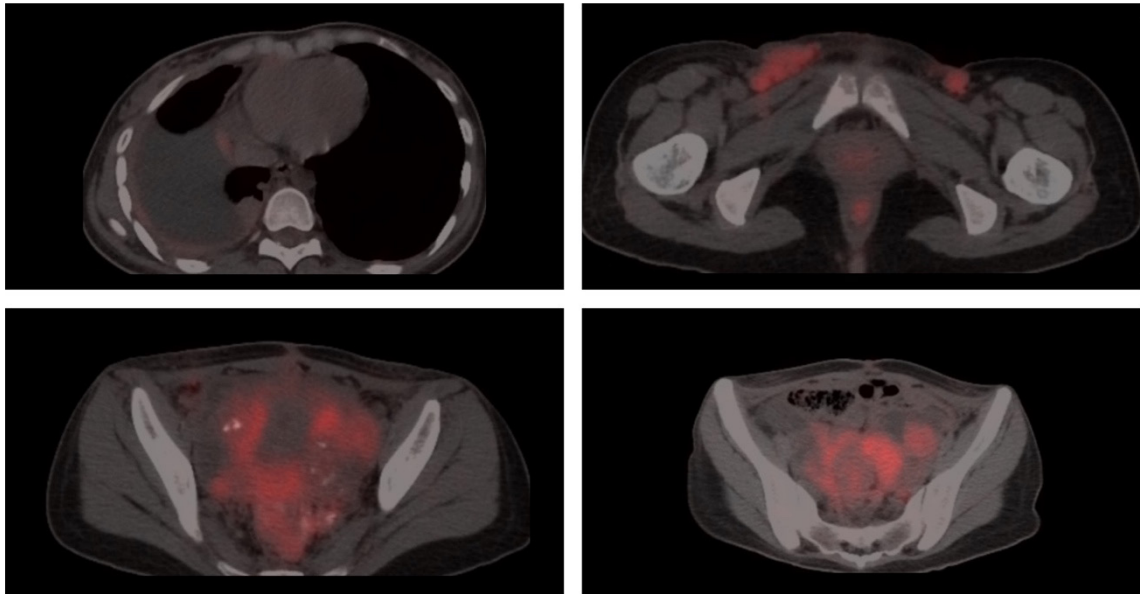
PET-CT Demonstrated a Primary Pelvic Malignancy Involving the Uterus, Cervix, Mesorectal Region, and Adnexa, with a High SUV (19.96) in the Cervical Lesion. Extensive Metastases were Identified in the Vulva, Perineum, Vagina, Regional Lymph Nodes, Peritoneum, Possibility of Mesenteric Seeding, and Right-Sided Pleural Effusion
